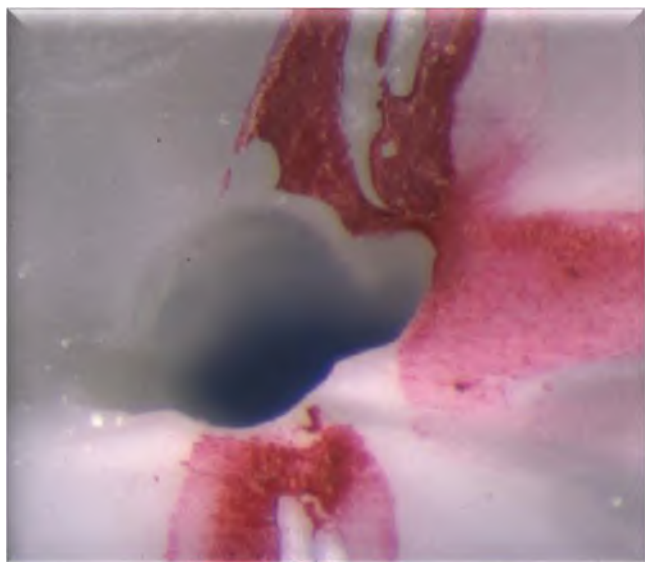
Postoperative image showing uninstrumented canal extensions that were cleaned by ultrasonic irrigation. The ultrasonic file was actively directed into the extensions.
